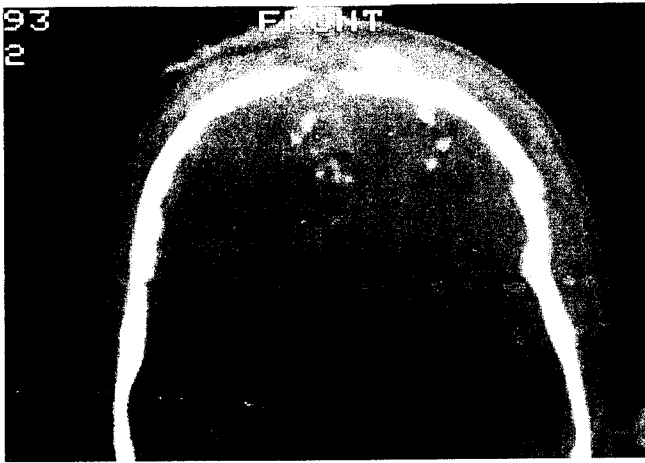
Computed tomographic scan of the brain (the bone window) shows the exit wound in the medial part of the frontal bone. Numerous bone fragments are visible in the brain.
